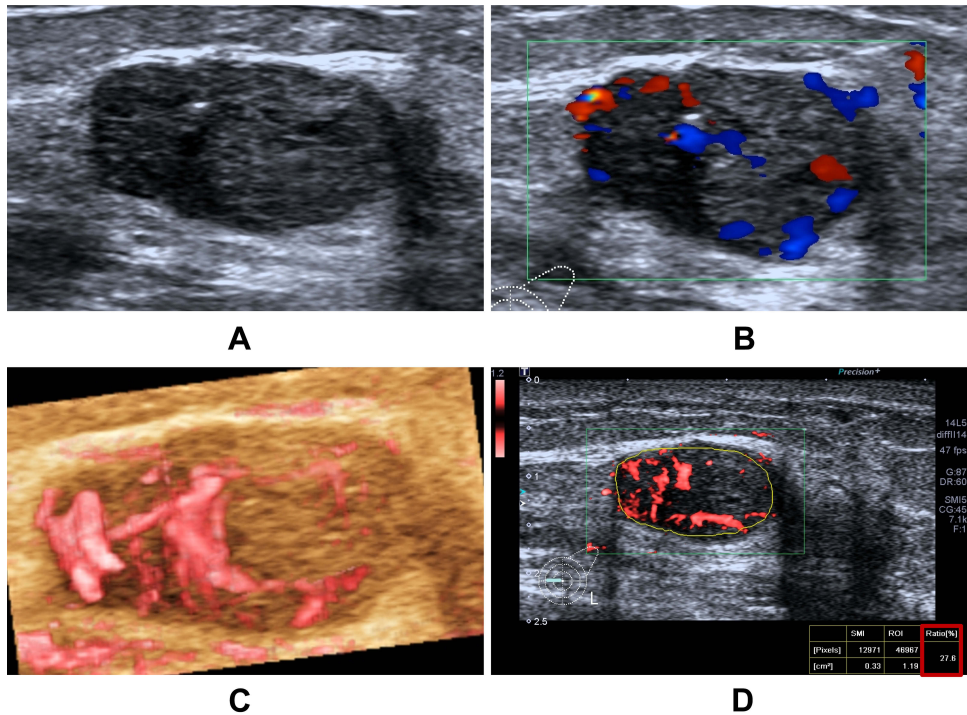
A 71-year-old woman with solid papillary carcinoma which maintained the original BI-RADS category 4B. (A) Grayscale ultrasonography shows an irregular echogenic lesion in the left breast, which was assessed as BI-RADS category 4B. (B) CDFI shows abundant spot and strip blood flow signals in the lesion. Green box: CDFI sampling frame. (C) SMI shows detailed and abundant vascular architecture with multiple thickened vessels. (D) When the ROI is set as the entire target lesion (yellow line), the vascular index of the mass is 27.6% (red box). Green box: SMI sampling frame.
